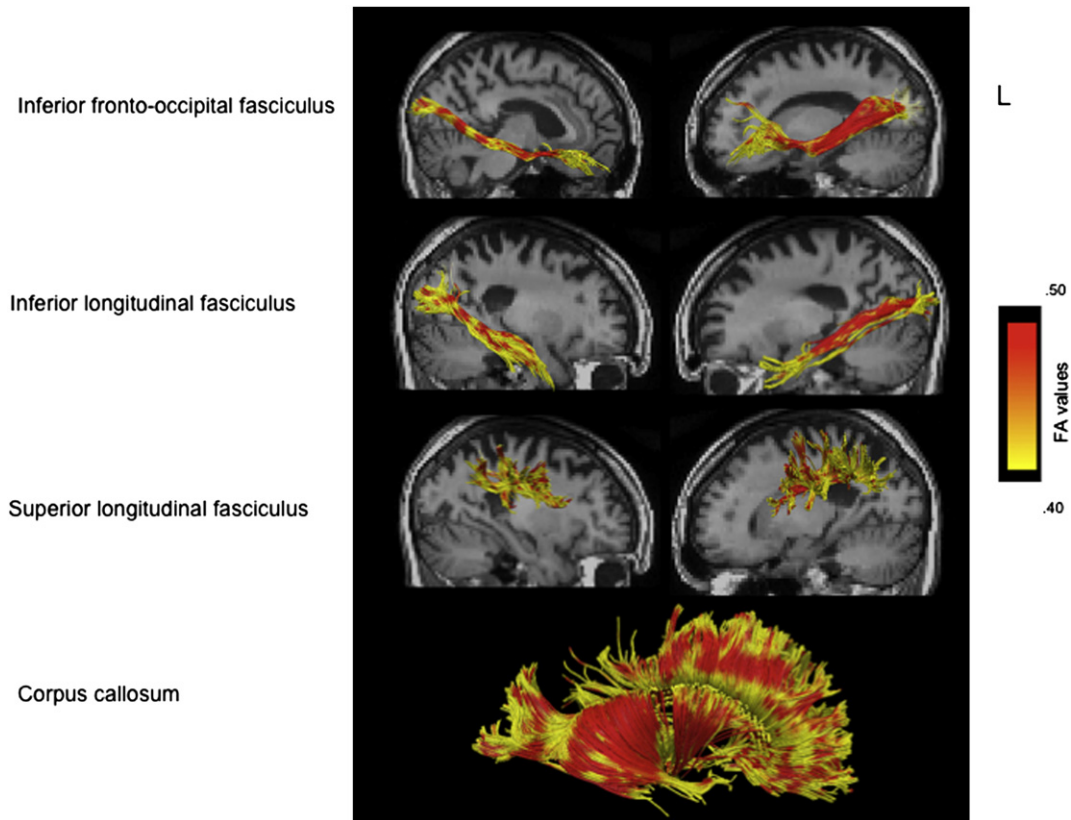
WM tracts are rendered as maps of FA for both hemispheres on the coregistered high-resolution T1-weighted images of the PCA patient. FA values are represented in a yellow-to-red color scale where yellow corresponds to lower values and dark red to higher values. Maximum damage is present in the right F-P SLF. Note the loss of fibers in the posterior part of CC.
